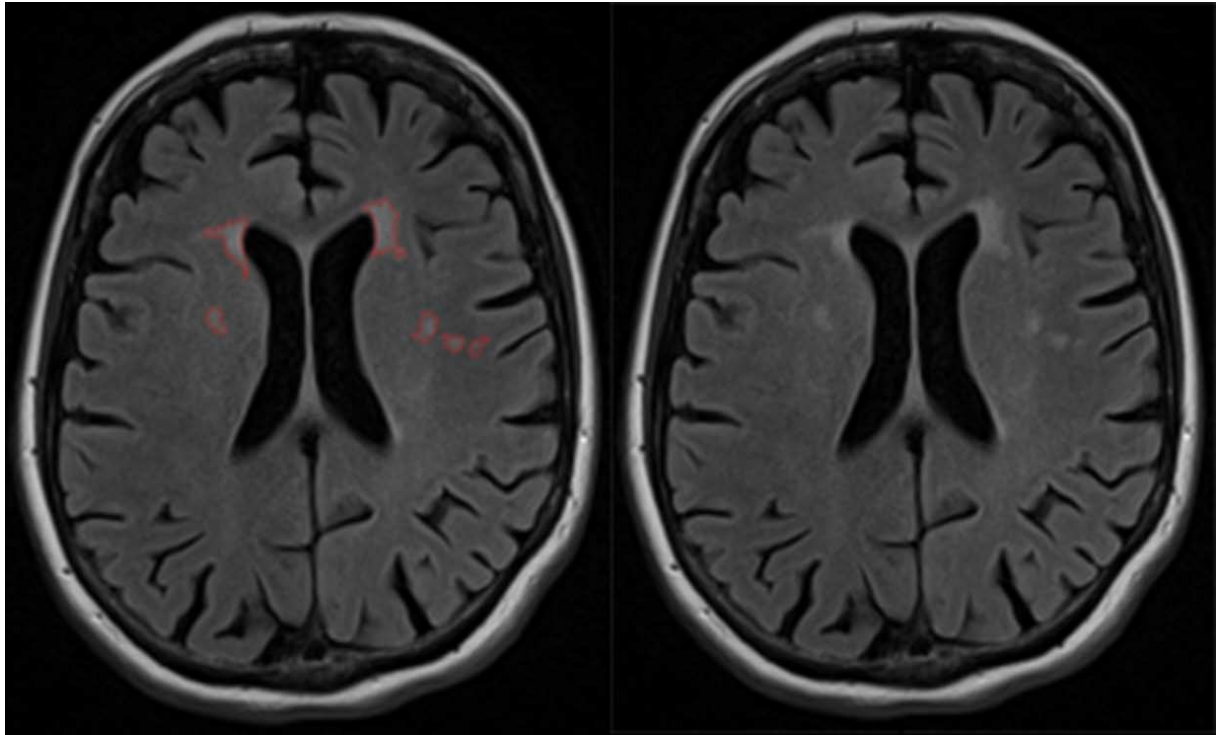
Representative axial FLAIR slice of one patient. The left image shows an example of lesion areas, outlined semi-automatically by the instructed rater using a custom written IDL program (Exelis Visual Information Solutions, USA). The right image shows the native FLAIR scan. Reused from our PLOS One publication (Birner et al., 2015).
